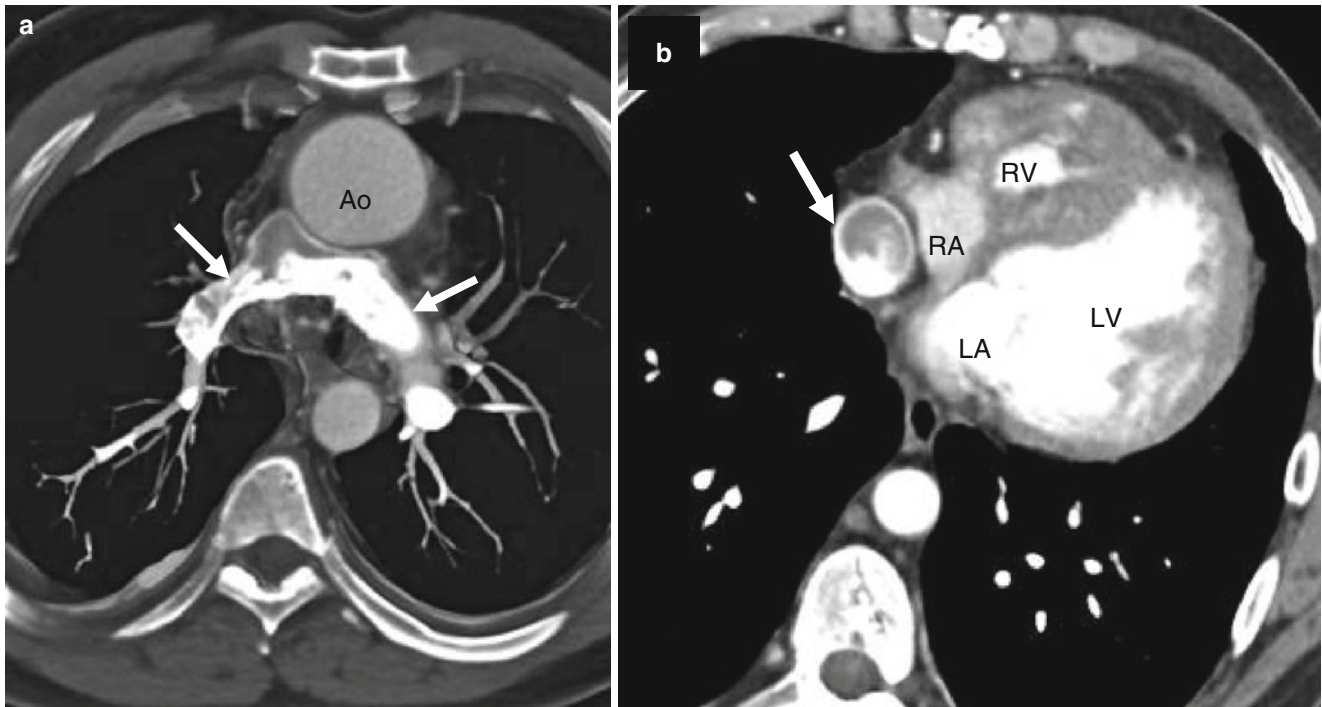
Pulmonary atresia with intact ventricular septum in a 32-year-old man with ventriculocoronary connections who underwent a Fontan procedure. Panel (a) is an axial computed tomogram (CT) showing the absence of the main pulmonary artery and slightly diminutive right and left pulmonary arteries (arrows). Panel (b) is an
